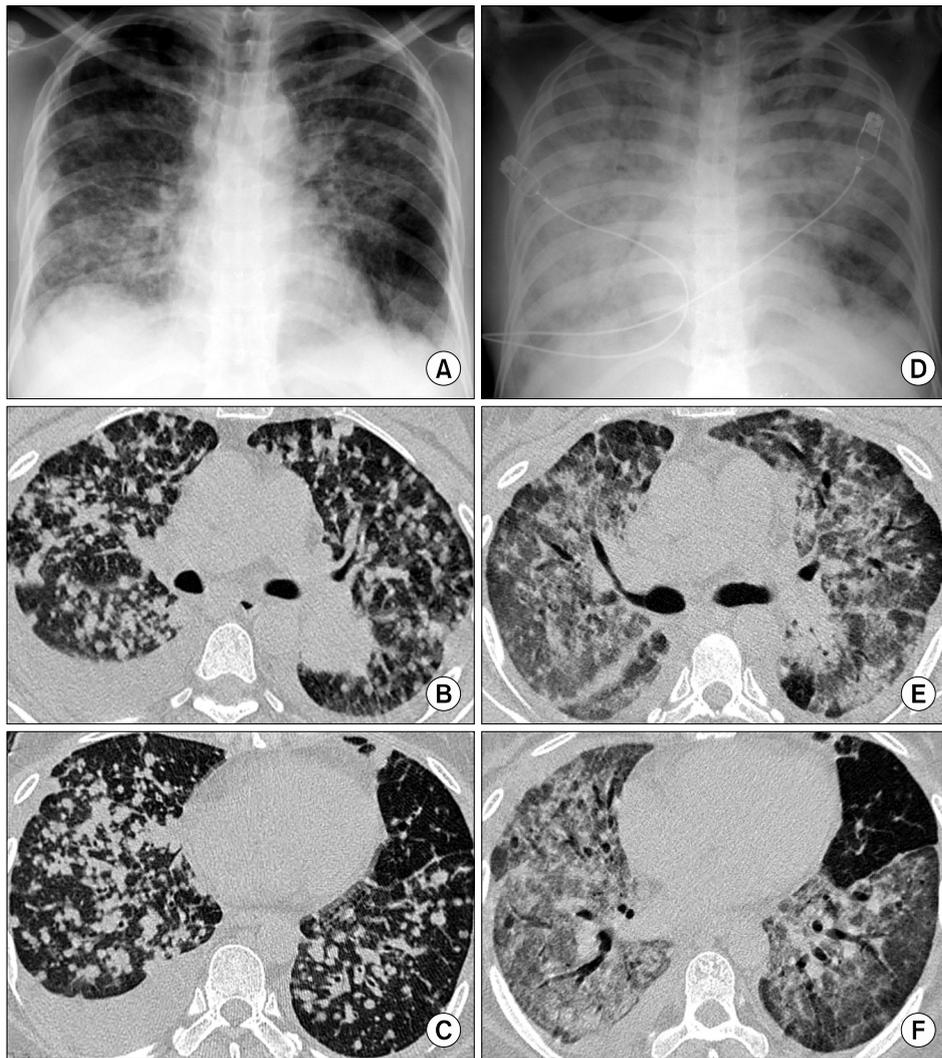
At the time of diagnosis, bilateral multiple lung nodules, right pleural effusion and a mass at the superior segment of the left lower lobe were observed on chest PA (A) and chest CT scans (B, C). At the 17th day after gefitinib was administered, the multiple lung nodules, pleural effusion and lung mass were shown to be decreased in size on the chest AP (D) and on similar slices from the pulmonary embolus protocol CT scan (E, F) while diffuse ground glass opacities were newly developed in both lungs.
